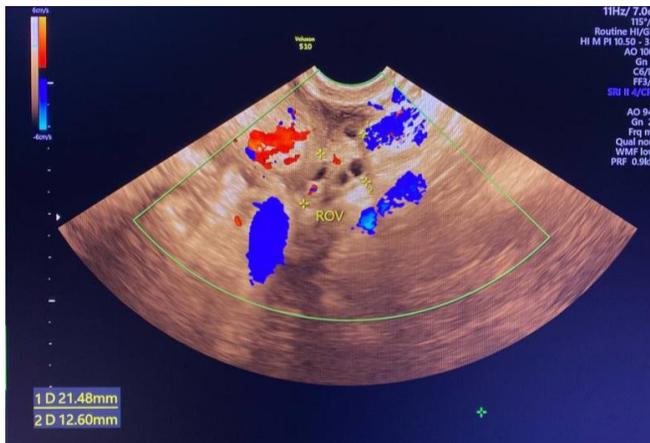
Transvaginal ultrasound showing the right ovary
